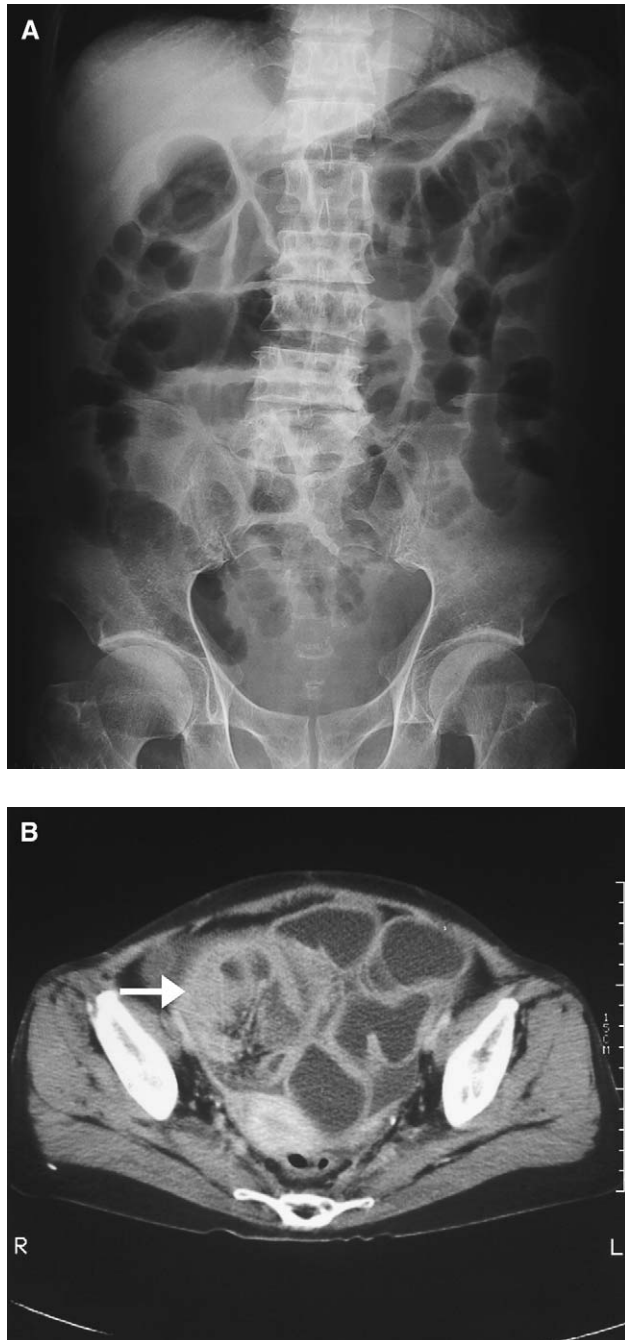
(A) The chronic and partial ileus seen in the plain abdominal radiograph in a patient with ileus 2 years after radiotherapy. (B) Computer tomography showing dilated bowel loops with thickening bowel wall (arrow).
